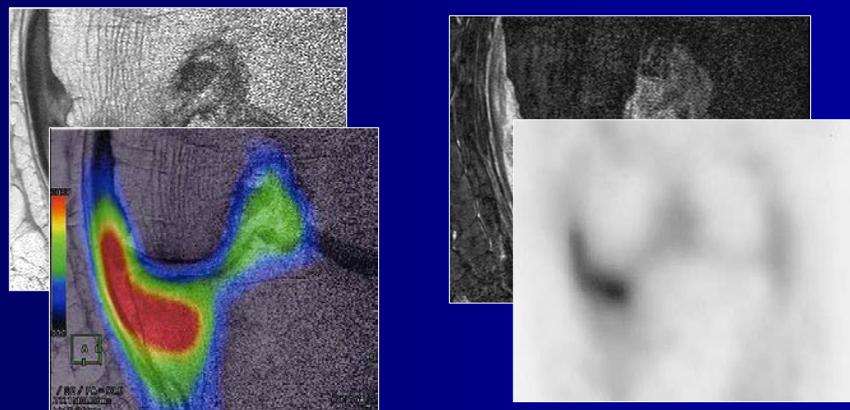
Nakamura H et al. Positron emission tomography with 18F -FDG in osteoarthritic knee. Osteoarthritis Cartilage 2007;15:673-81.
